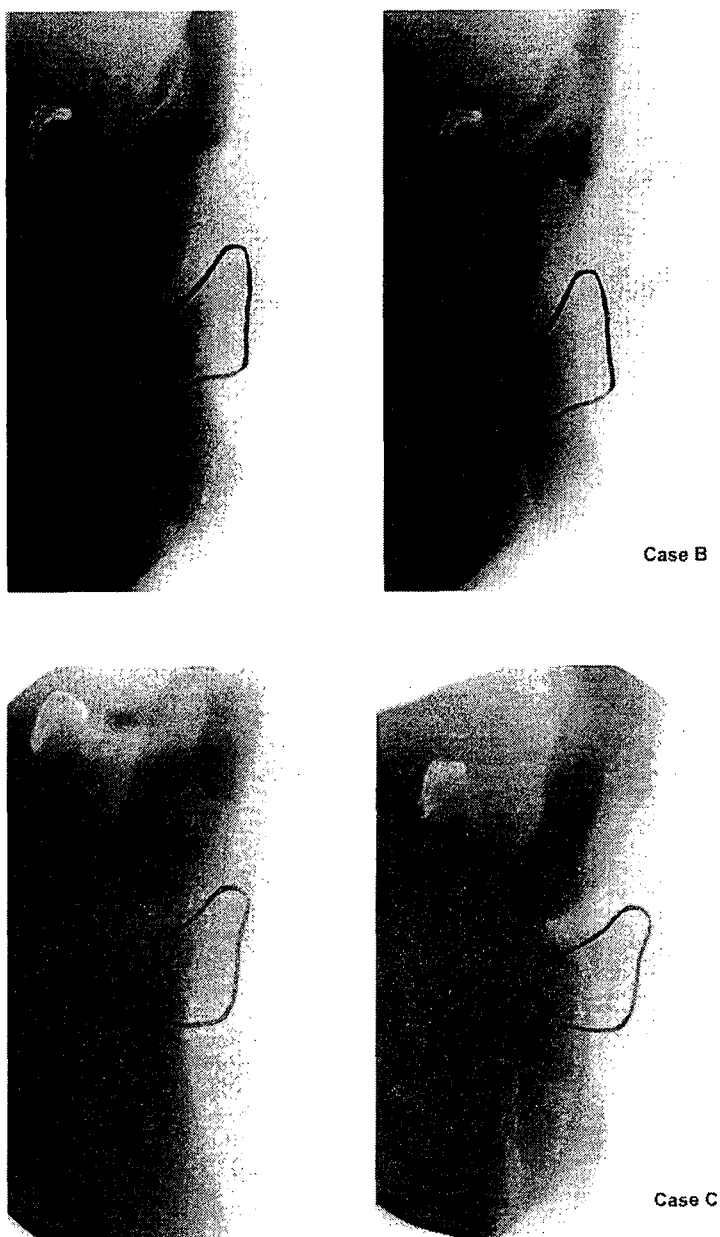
The lateral x-ray films of the neck during the interrogative stress contrast of sentence terminal(left) and the pitch lowered contrast of sentence terminal (right) for the case A, B, C. The retropharyngeal space from posterior cricoid line to anterior cervical spine shows narrowed in the interrogative stress and widened in the stress lowered.
